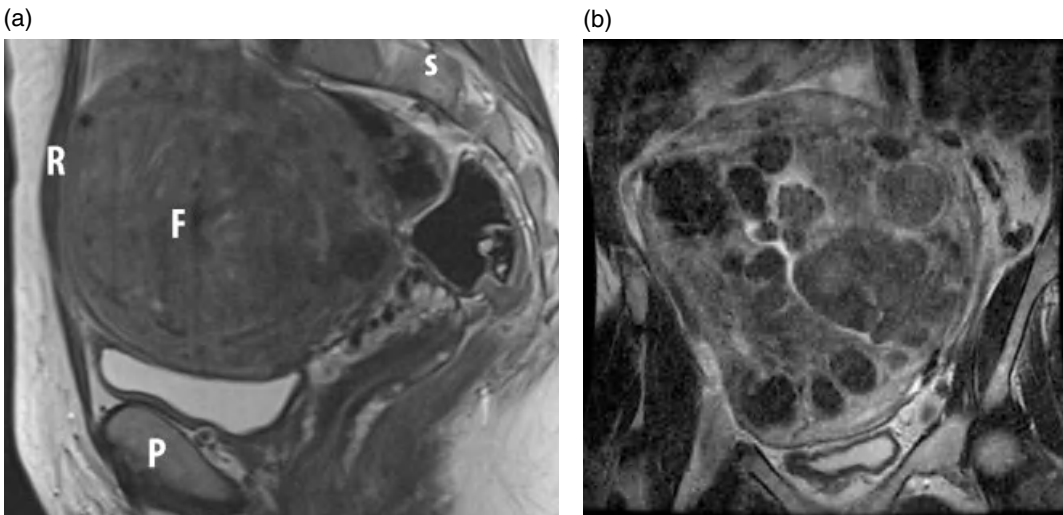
Ideal candidate for MRgFUS (a) and example of a candidate who is not ideal for MRgFUS (b). (a) Sagittal T2-weighted MR image demonstrating a fibroid (F) of moderate size, and of intermediate to low signal intensity. The uterus lies just posterior to the anterior abdominal wall. F, fibroid; S, spine; P, pubic bone; R, rectus abdominis muscle. (b) Coronal T2-weighted MR image demonstrating innumerable fibroids (well-defined areas of low signal (dark) and intermediate signal) of varying sizes throughout the uterus. It is difficult to determine which fibroid is most symptomatic to target, and not possible to target all in one treatment sitting.
